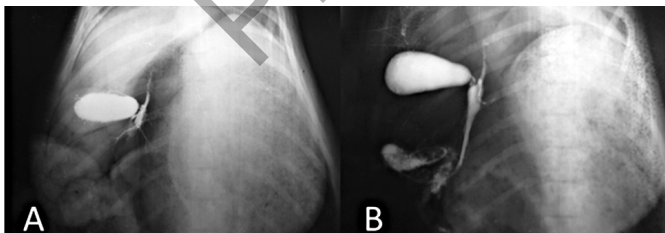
A. Model of bile duct obstruction (postoperative day 7), the x-ray shows no bile drainage to the duodenum. B. Common bile duct is reconstructed with bile duct equivalent (postoperative day 7), there is no sign of stricture or bile flow obstruction.
